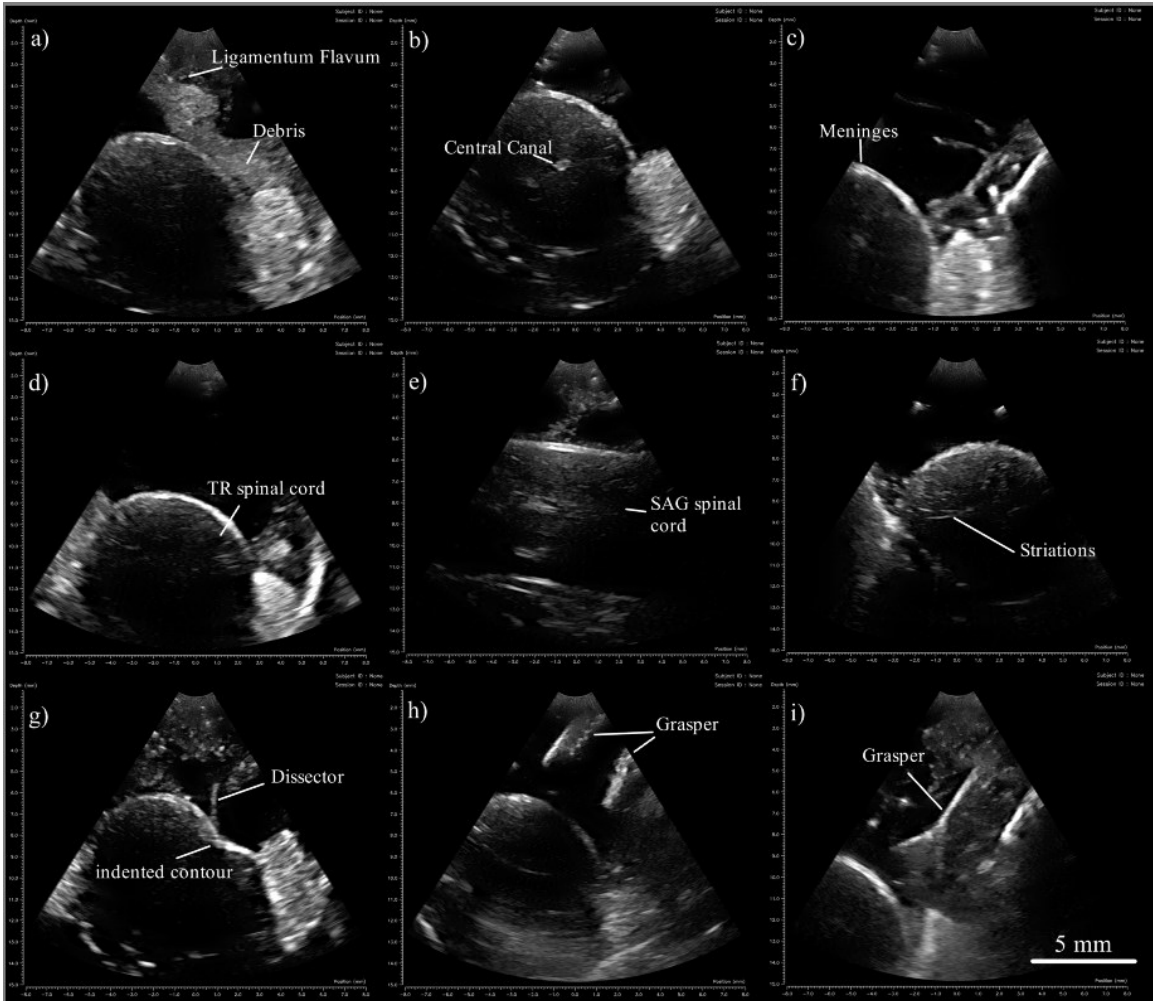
Ultrasound images of: a) TR spinal cord with anterior ligamentum flavum and tissue debris b) TR spinal cord with visible central canal c) partial TR spinal cord showing fine structures in the anechoic region d) TR spinal cord e) SAG spinal cord with central canal visible f) echogenic striations within TR spinal cord g) indented TR spinal cord contour from a dissector h) TR spinal cord with forceps in image i) TR spinal cord with smaller graspers in plane.
